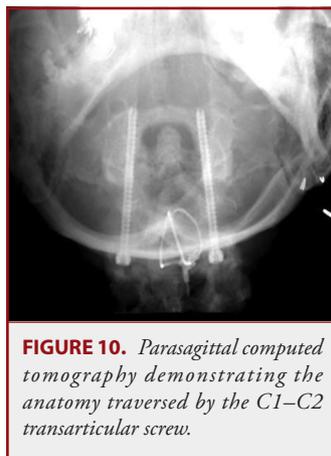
Parasagittal computed tomography demonstrating the anatomy traversed by the C1–C2 transarticular screw.
